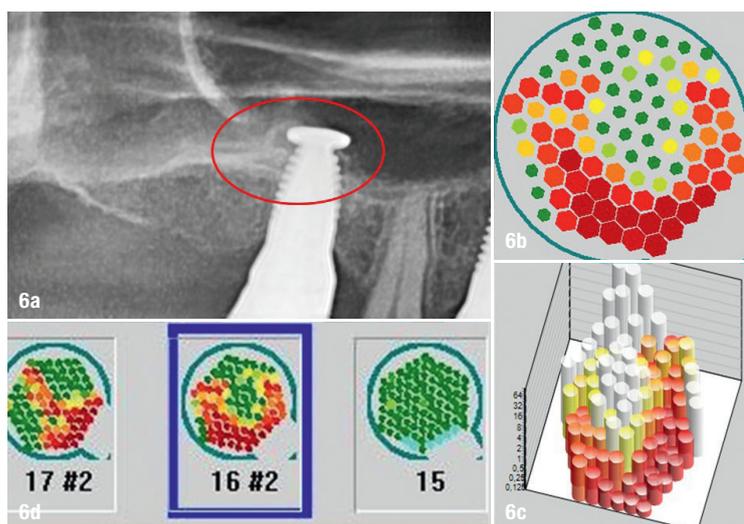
Radiograph showing implants in areas #24 and 25 and inconspicuous bone around the implants (a). CaviTAU image clearly displaying the straight line where the implant (in green) comes into contact with the obviously osteolytic jawbone in red (b). The white columns show the implant, and the red columns indicate the diminished bone density of the directly adjacent jawbone (c). In contrast to the radiograph, the measurement by CaviTAU of the bone density adjacent to the implants displays diminished bone density in red (d).
